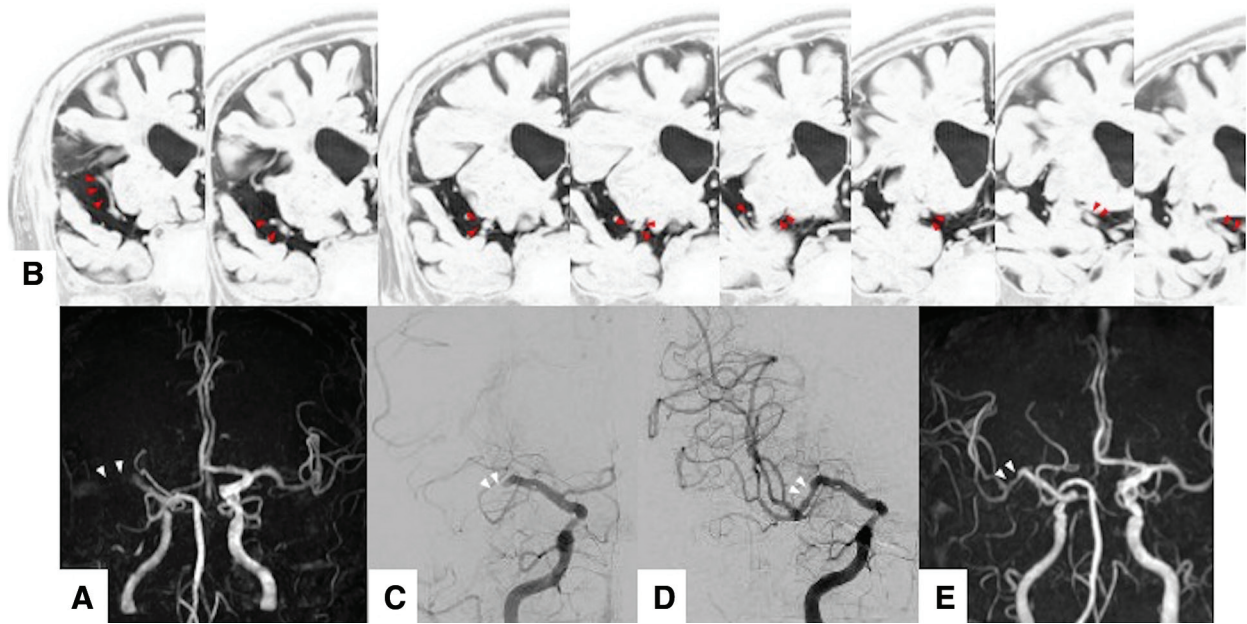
A 77-year-old-man with repeated left hemiparesis and dysarthria. (A) MRA presents right MCA occlusion. The occlusion point is indicated by the arrowheads on MRA. (B) It is possible to visualize the total occluded M1 (horizontal segment) by MAS-MRI. The occluded MCA can be observed by MAS-MRI. The arrowheads indicate M1 from the proximal side to the distal side of the occlusion point. M1 was steeply descending. Part of the blood vessel wall was
